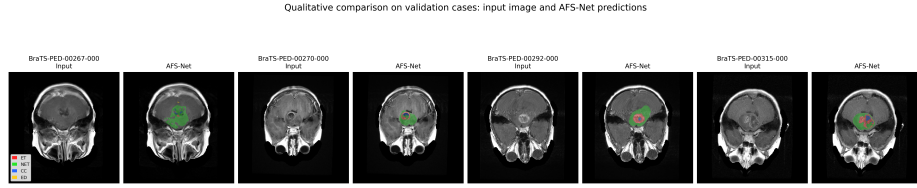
Qualitative comparison on representative validation cases. For each case, the input MRI slice is shown together with the corresponding AFS-Net prediction. The visualizations provide visual support for the quantitative DSC and NSD results in Table 2.
